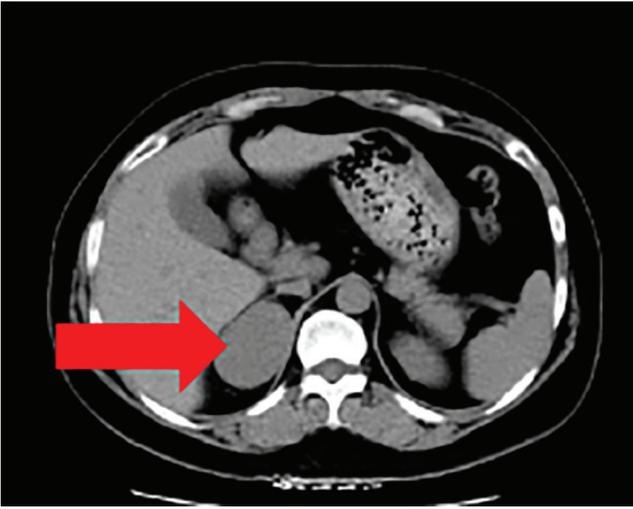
Cross-sectional adrenal CT scan. A cross-section of the adrenal gland revealed a tumor (45x40 mm; arrow) on the right adrenal gland with a CT value of 46 Hounsfield Units and uniform density. The presence of pheochromocytoma or lymphoma was considered. CT, computed tomography.
